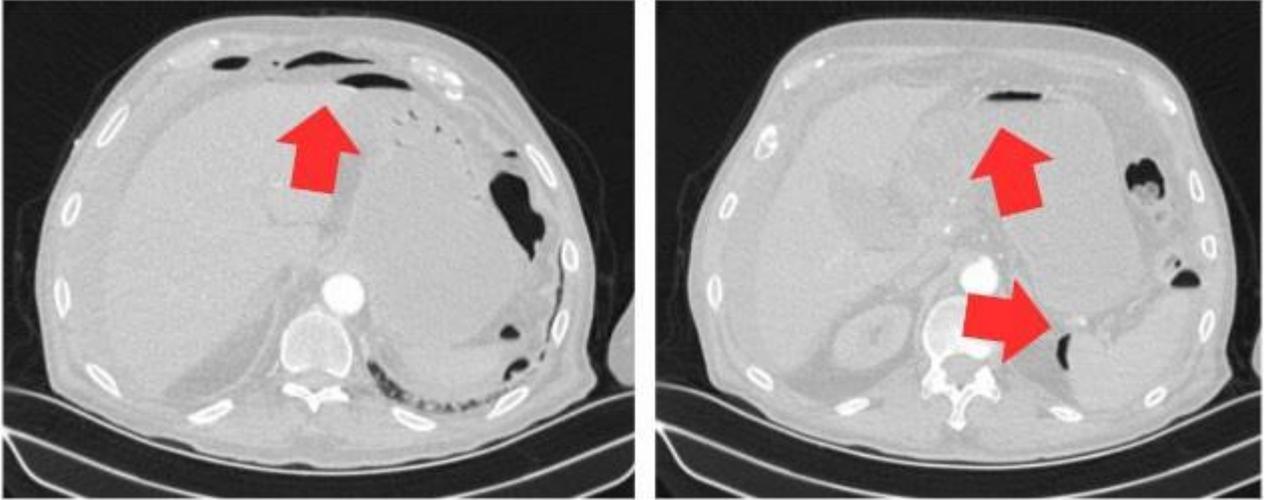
Free air views for the abdomen in the lung window of the CT scan (arrows).
